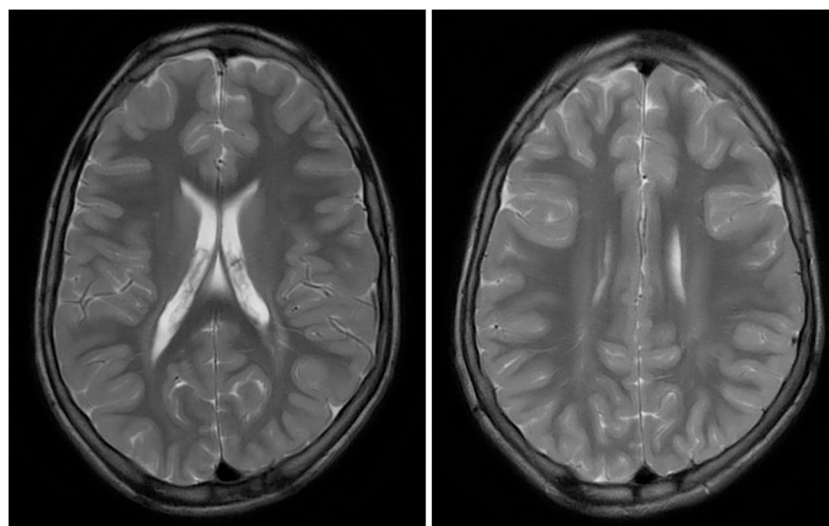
Axial T2-weighted brain MRI of the proband.
